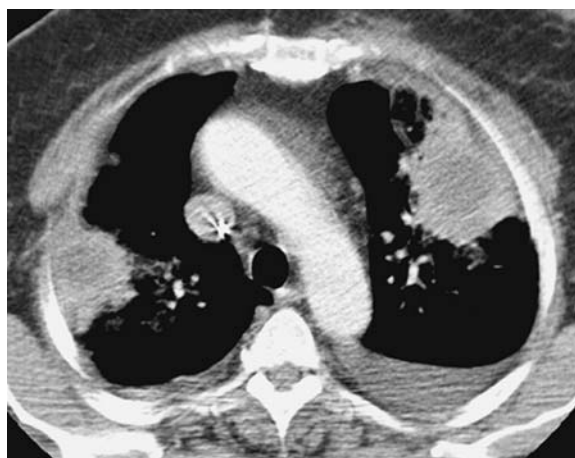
Transverse CT section after double-lung transplantation. CT shows large peripheral enhancing masses corresponding to fungal infection
